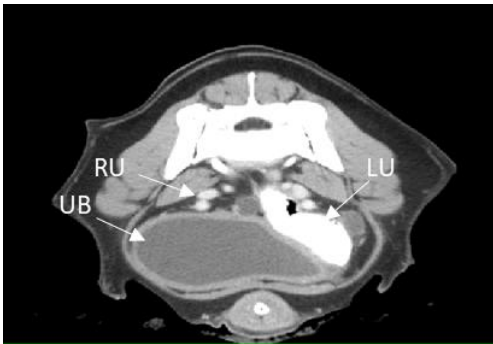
CT image of the right and left ureters and urinary bladder: UB – urinary bladder, RU – right ureter, LU – left ureter.
